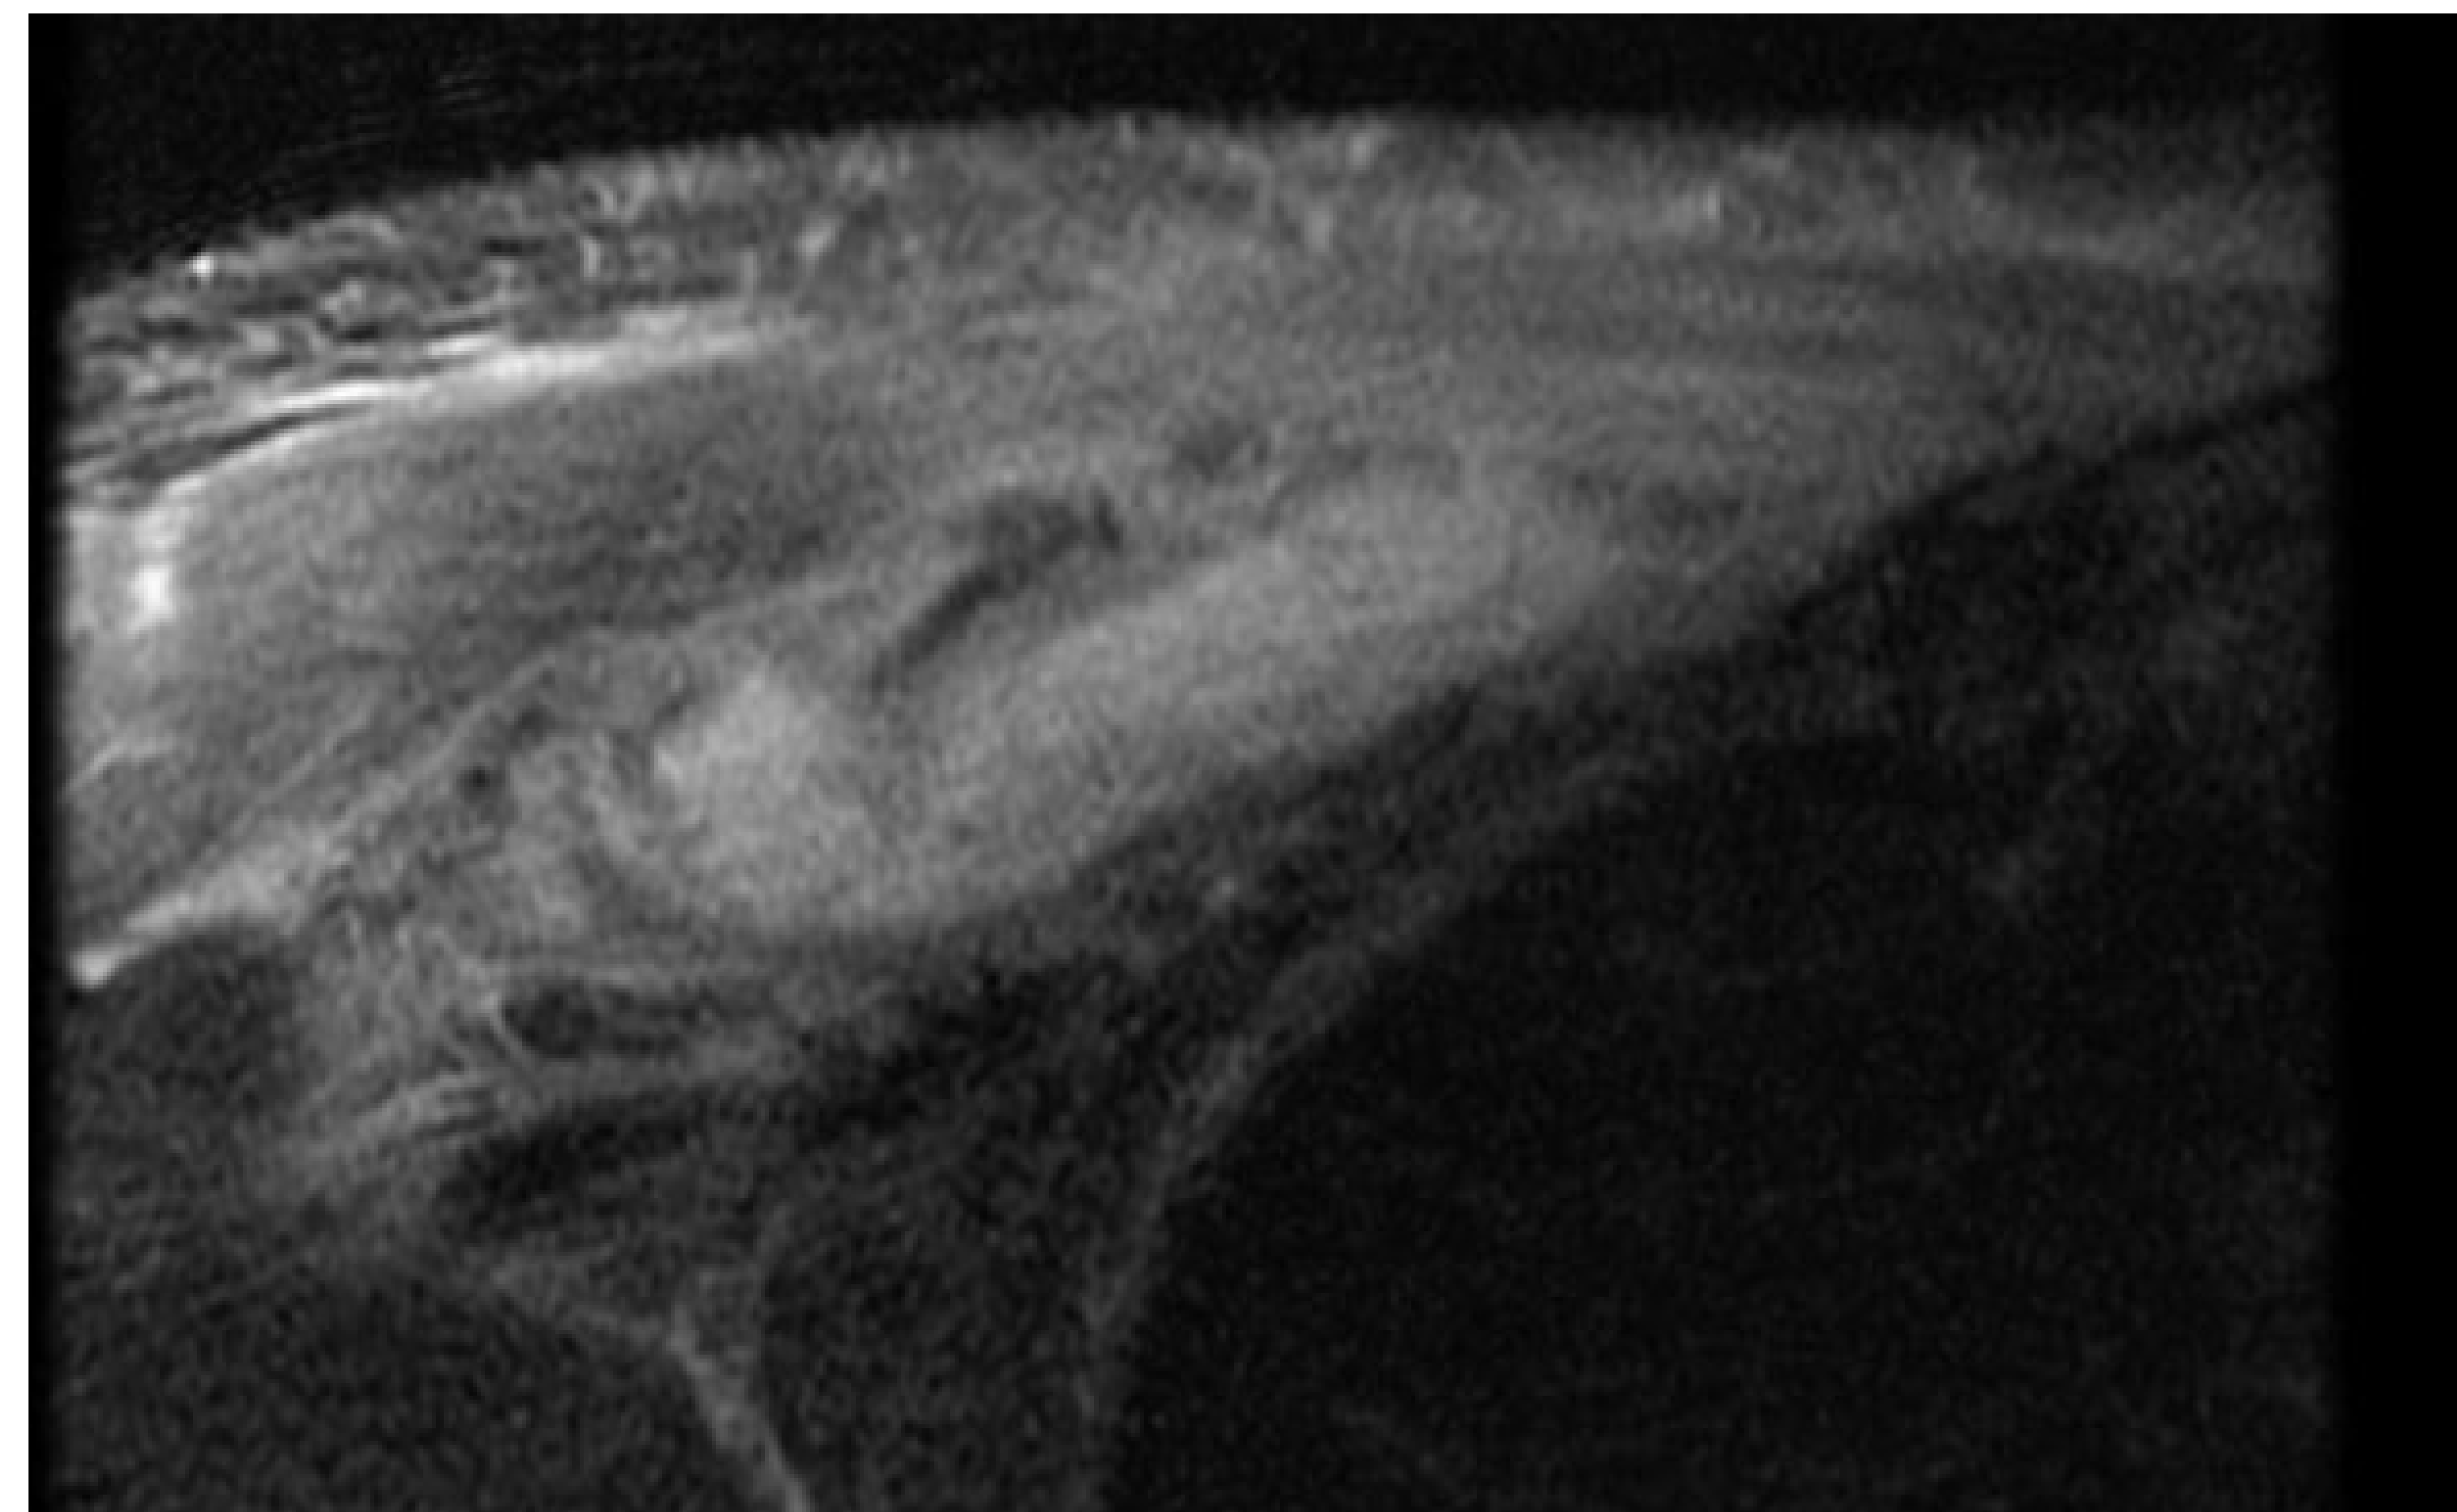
Axial T2 STIR MRI of right chest demonstrating diffuse edema and fluid collection in pectoralis minor
